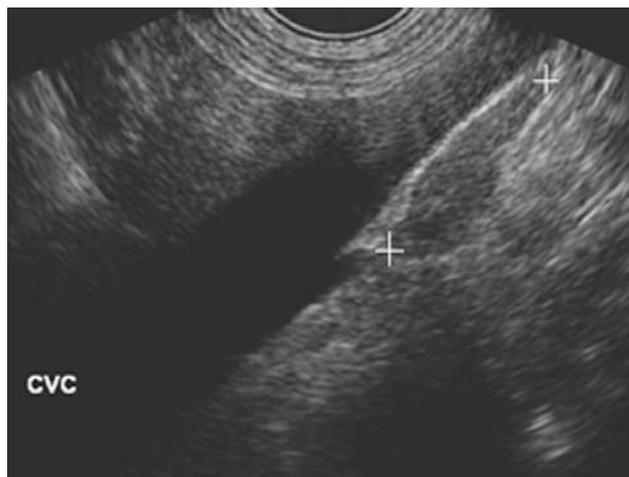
Longitudinal ultrasound image of a normal right adrenal gland. CVC = caudal vena cava.
